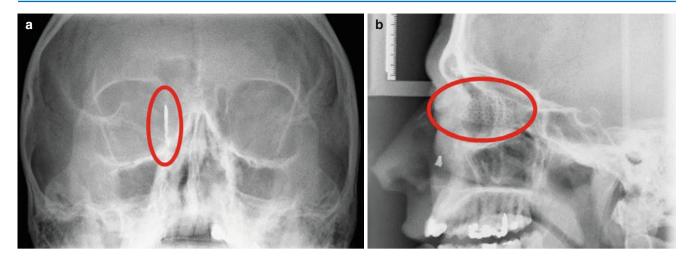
Postoperative plain films show a satisfactory position (a, b). Red circles show the plate
